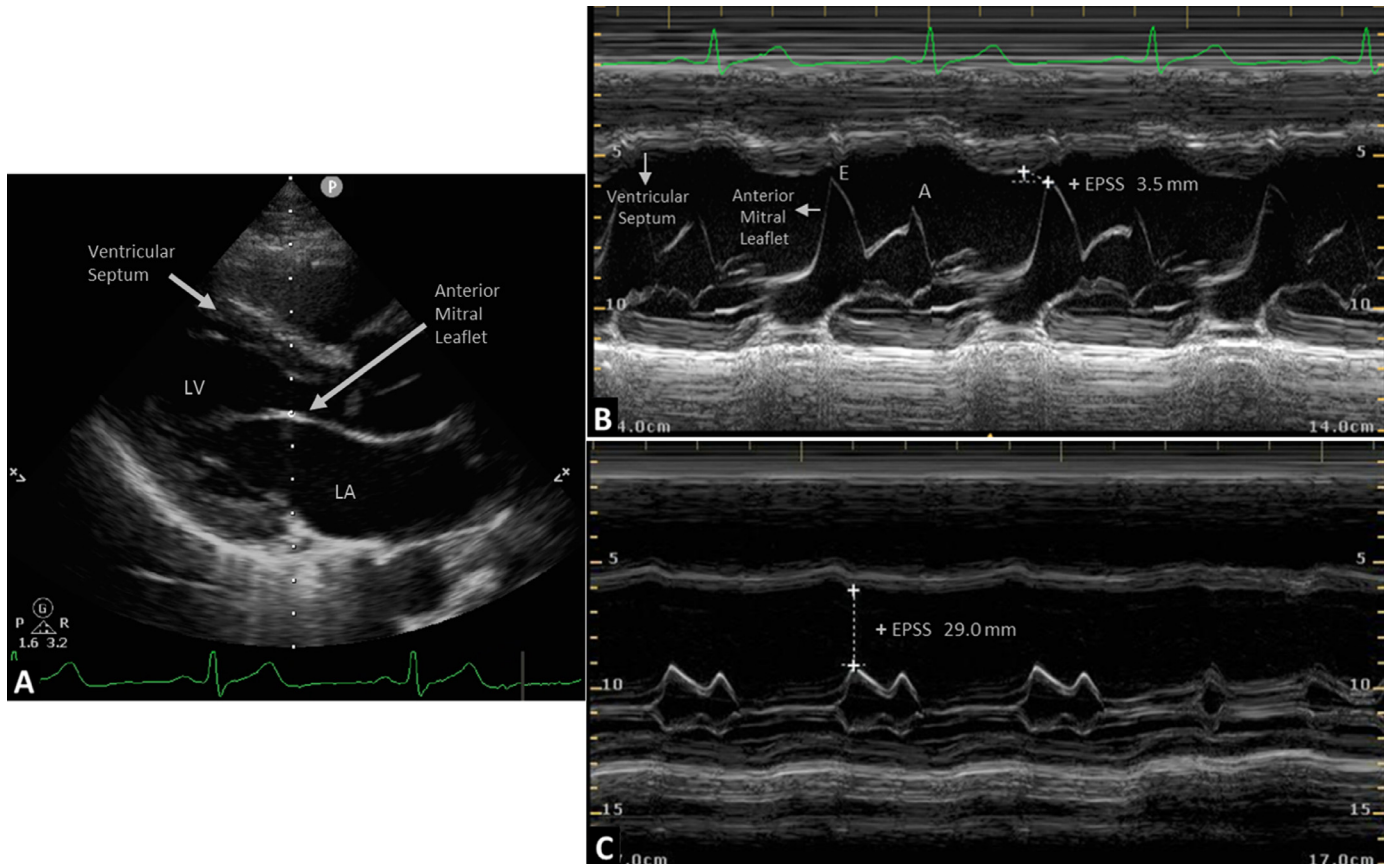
E-point septal separation by transthoracic echocardiography. (A) Two-dimensional image of parasternal long-axis view describing the image acquisition before M-mode imaging of E-point septal separation; the M-mode line (white dotted line) is placed through the ventricular septum (upper arrow) and the tip of the anterior mitral leaflet (lower arrow); then, M-mode imaging can be recorded. (B) M-mode image of normal E-point septal separation (3.5 mm) suggesting normal left ventricular systolic function. The ventricular septum (upper vertical arrow) and the anterior mitral leaflet (lower horizontal arrow) are depicted across several cardiac cycles. “E” indicates the early opening of the anterior mitral leaflet caused by early diastolic filling; “A” corresponds to the late opening of the anterior mitral leaflet caused by atrial contraction during late diastolic filling. E-point septal separation is measured as the distance between the anterior mitral leaflet and ventricular septum at early diastole (ie, at “E”). (C) M-mode image of abnormal E-point septal separation (29.0 mm) suggesting left ventricular systolic dysfunction. EPSS, E-point septal separation; LA, left atrium; LV, left ventricle.
